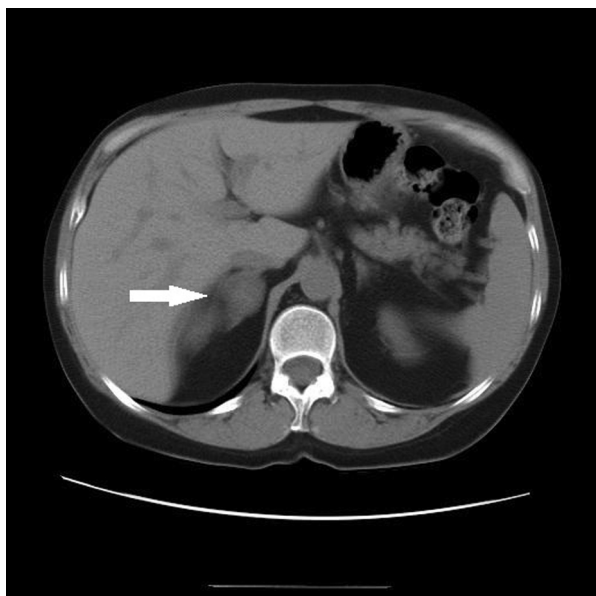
CT scan showing a 2.7 cm right adrenal adenoma (arrow).
